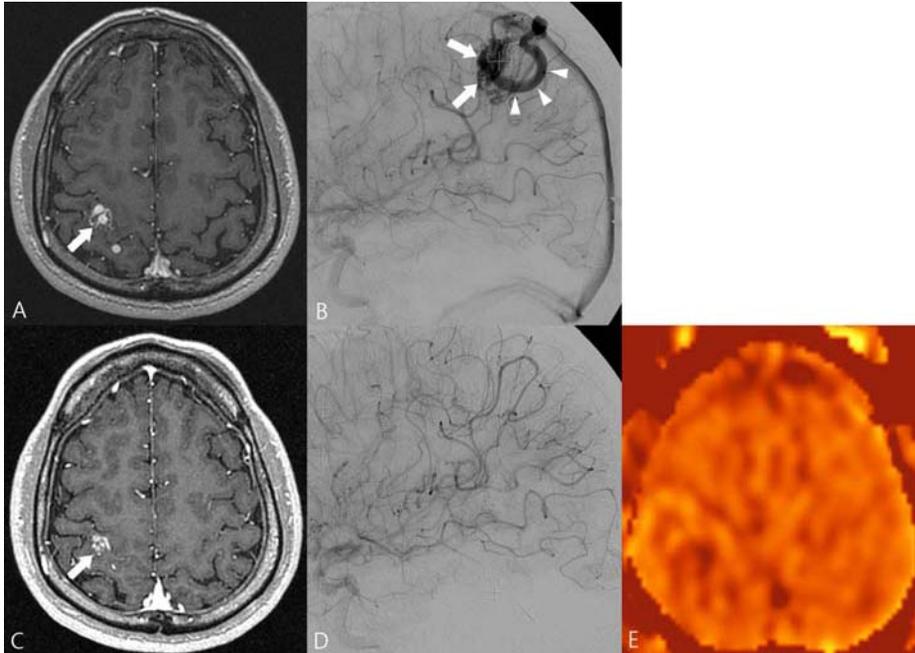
A 28-year-old male who underwent GKS for a right parietal AVM. (A-B) Axial T1-weighted post-contrast image (A) and DSA (B) performed 38 months after initial GKS as a GKS-planning study. (A) A few enhancing tubular structures (arrow) indicate residual AVM at the right parietal lobe. (B) Lateral DSA confirmed a residual AVM (arrows) supplied by the right MCA and cortical vein (arrowheads) draining into the superior sagittal sinus. (C-E) Axial T1-weighted post-contrast image (C), DSA (D), and axial ASL image (E) performed 88 months after initial GKS and 50 months after second GKS. (C) Remaining clustered enhancing foci at the right parietal lobe gave rise to the suspicion of residual nidus. (D) However, the AVM was completely obliterated without demonstrable nidus on DSA. (E) On ASL, no abnormal venous signal intensity was noted in the corresponding area.
